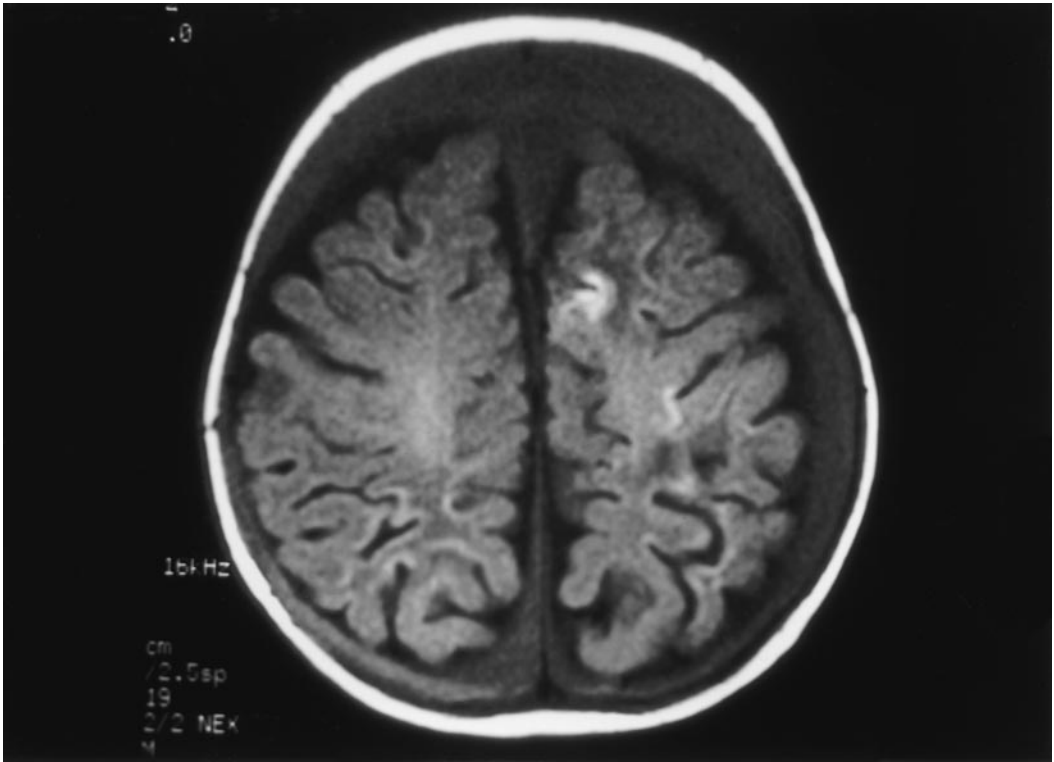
In patient 8, MRI showed a chronic subdural hematoma and a hemorrhagic left frontal contusion.
